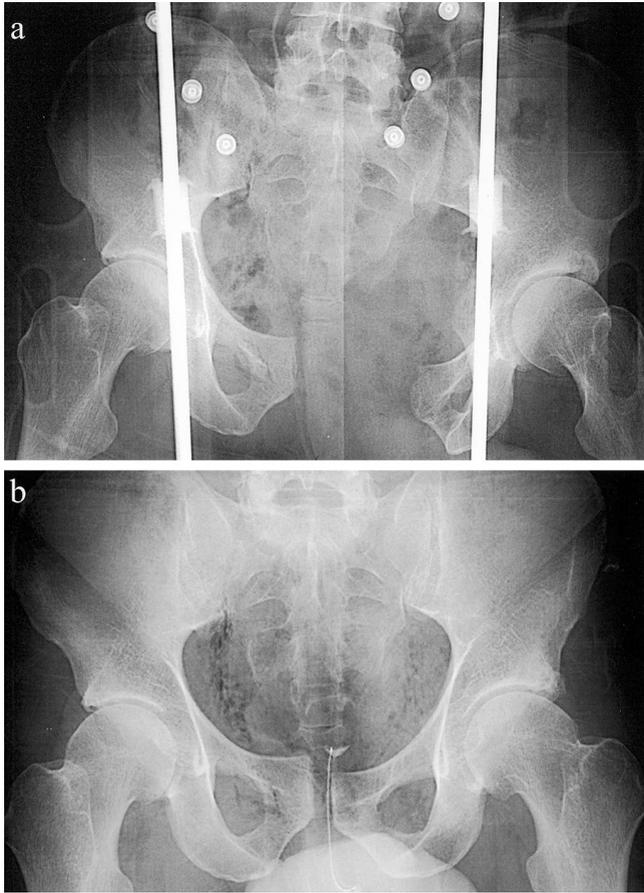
Anteroposterior radiograph of the open-book pelvic fracture of case 1, demonstrating significant disruption of the left sacroiliac joint. (a) Before intervention. (b) After emergent application of a tightly wrapped sheet around the pelvis, demonstrating near-anatomic reduction of the pubic symphysis and the SI joint.
